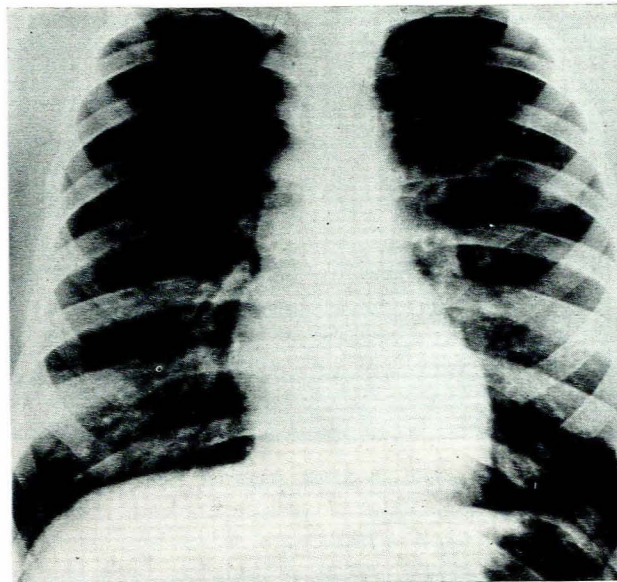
Postero-anterior roentgenogram of chest. A mass is present behind the heart.
